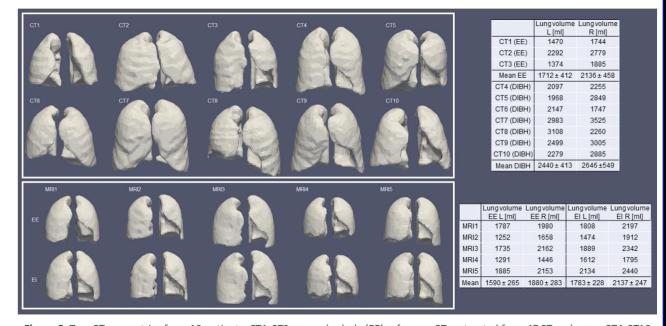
Top: CT geometries from 10 patients. CT1-CT3 are end exhale (EE) reference CTs extracted from 4DCTs, whereas CT4-CT10 were acquired during deep inspiration breath hold (DIBH). Bottom: MRI lung geometries from 5 volunteers at end exhale (EE) and end inhale (EI) reference phases from the 4DMRIs. The corresponding volumes of the segmented lungs (left and right separately) are listed in the tables.
